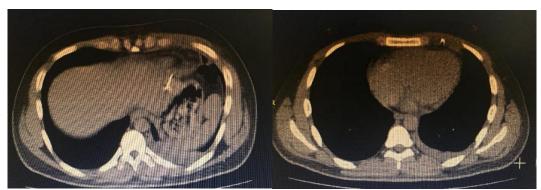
Axial view of non-contrast chest CT scan: hemothorax and foreign bodies.
